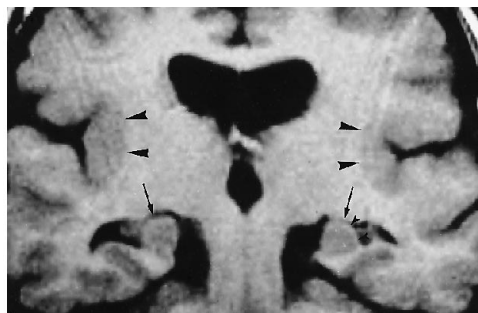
Patient 11: bilateral malformation of the hippocampal formation. T1-weighted oblique coronal section: the hippocampal formation had an unusual vertical orientation and a globular shape (arrows). The fimbria and the alveus were poorly delineated (small arrowheads). Ventricles were enlarged. The cortex of the temporal lobe had an apparently normal gyration. Areas of extratemporal neocortex appeared thicker than normal with shallow sulci (large arrowheads).
